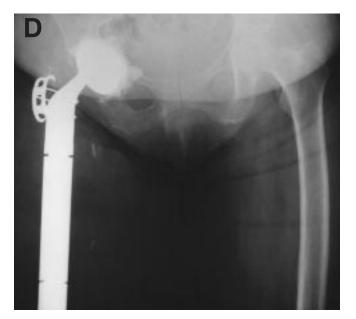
(A) Plain radiographs of the fixation of a multiple myeloma of the lesser trochanteric region of the proximal femur which has progressed despite radiation therapy and fractured with a plate and screws in place. (B) Postoperative radiograph following resection of the proximal femur.
